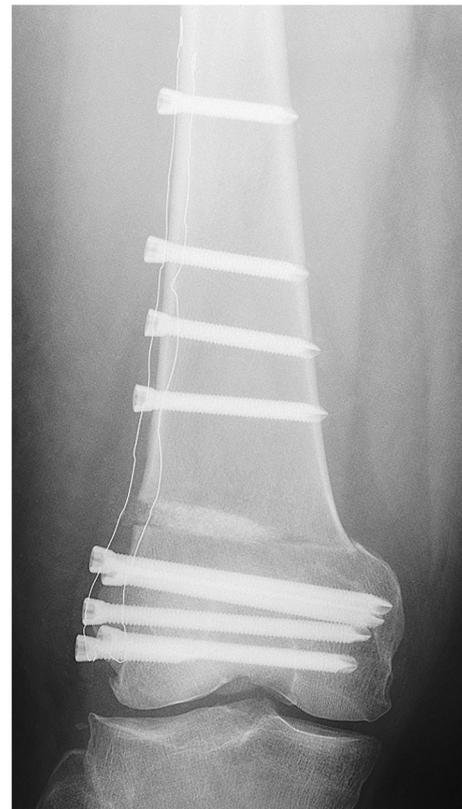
This radiograph of the patient from Figs. 1 and 2 shows a typical medial cortical fracture with displacement that was seen during an early postoperative visit. This patient had a late fracture (occurred after surgery) without any known trauma.
